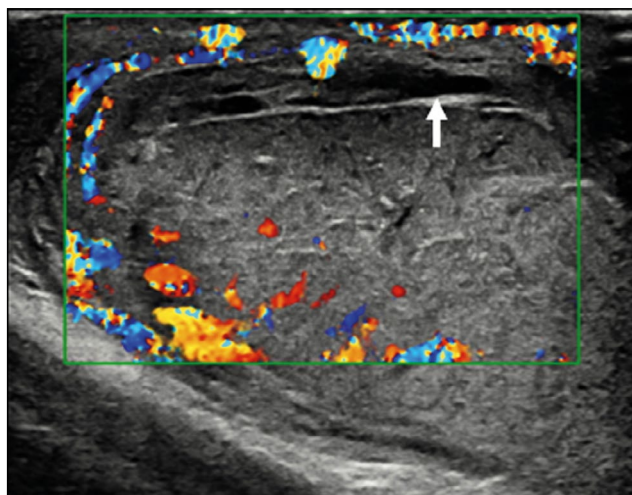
Color Doppler ultrasonography image showing an irregular testicular morphology with an avascular area at the breaking point (arrow).
